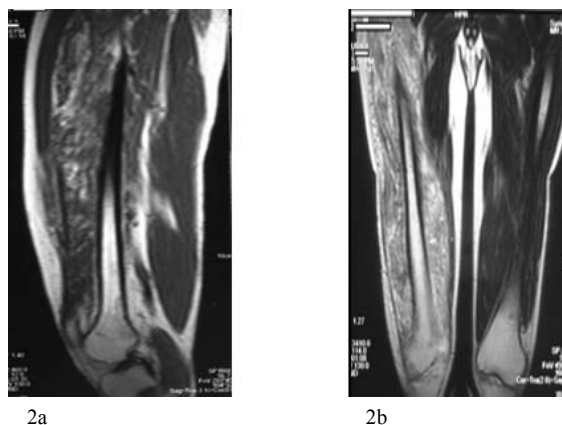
MR findings of the lesion. (2a) a coronal T1-weighted MR image shows an isointense area compared to skeletal muscle surrounded by inhomogeneous hyperintense areas. (2b) a sagittal T2-weighted MR image demonstrated a high signal intensity mass with low signal intensity lace-like structures within that
